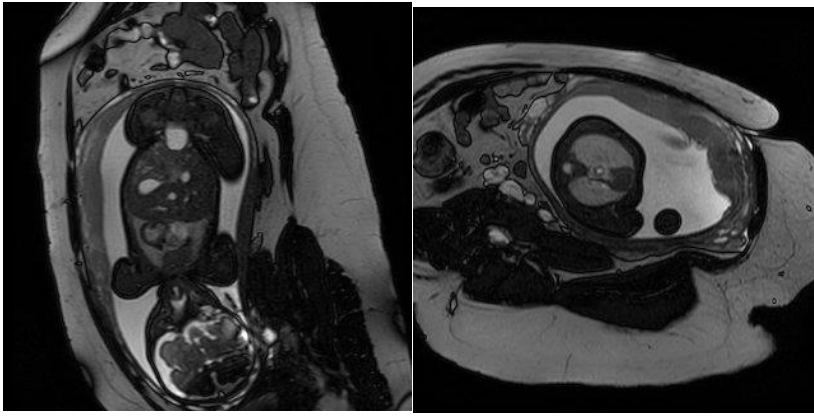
T2 weighted images obtained on a 1.5T MRI scanner showing (a) oligohydramnios in a 31<sup>+1</sup> week fetus with prelabour preterm rupture of membranes (b) normal amniotic fluid volume in a 28<sup>+1</sup> week fetus.
